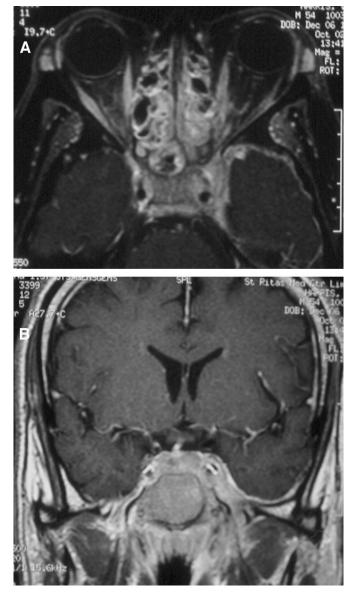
Axial (A) and coronal (B) T1-weighted, gadolinium-enhanced brain magnetic resonance imaging in a patient with left third and sixth nerve palsies. Enhancement and enlargement of the left cavernous sinus consistent with an infiltrative infectious, inflammatory, or neoplastic etiology is seen. Also seen is enhancement of the dura surrounding the left temporal lobe tip. Biopsy of the sinuses revealed squamous cell cancer.
